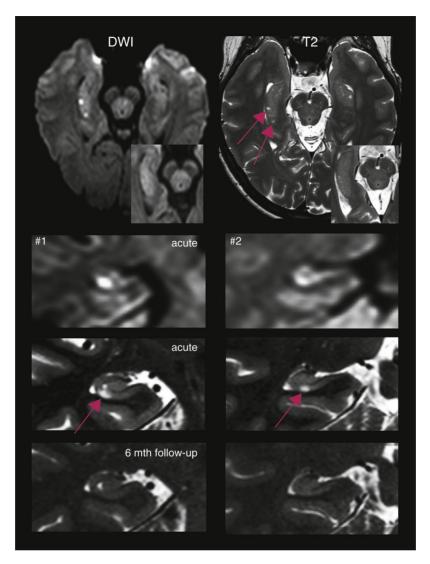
High-resolution MRI (3T) in TGA showing typical hippocampal lesions in the CA1 region of the cornu ammonis. Follow-up 6 months after the TGA shows a complete resolution of lesions. Modified after Bartsch and Deuschl (2010), used with permission from Elsevier.
